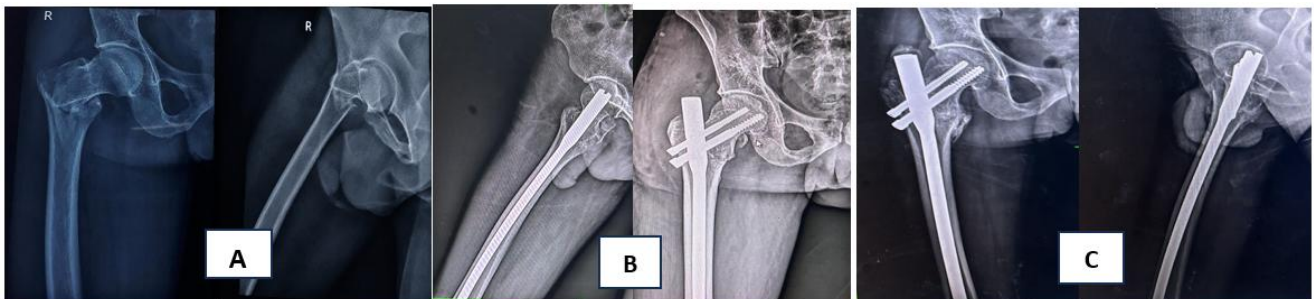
Case-PFN-2 screw: (A) Pre-op X-ray; (B) Immediate post op X-ray; (C) X-ray at 6 months follow up.
